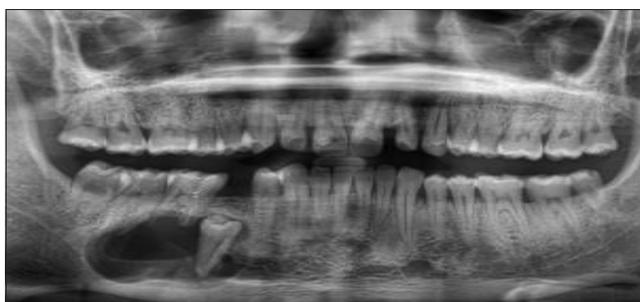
Panoramic radiograph showing formation of bone over the inferior border post marsupialization
